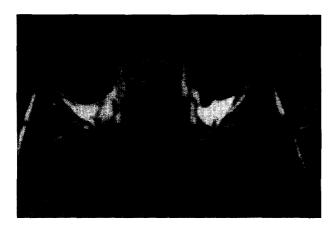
T1-weighted magnetic resonance imaging scan of patient 2 after contrast agent administration showing left intraocular tumor which is hyperintense compared to vitreous.
